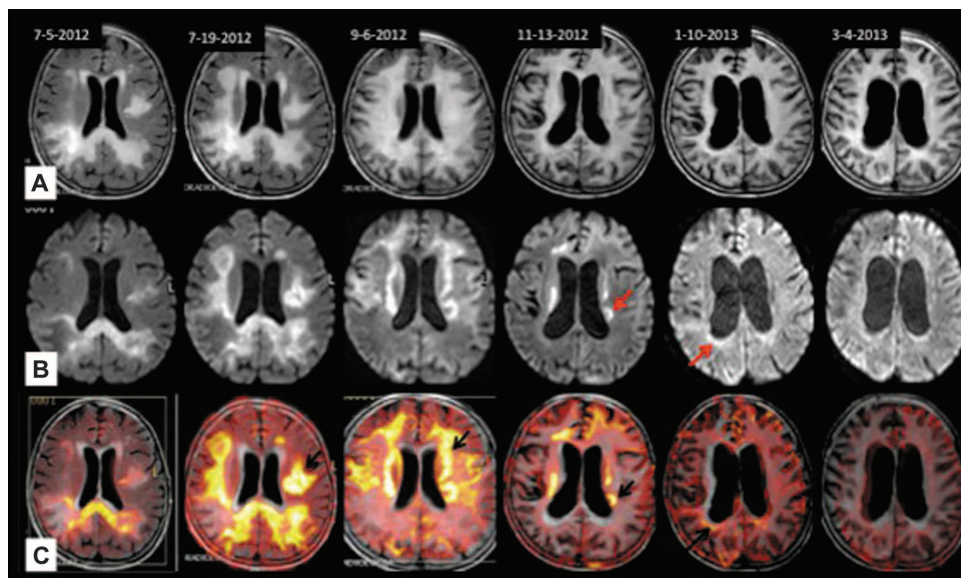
Evolution of PML lesions by magnetic resonance imaging in patient 5228. The patient was initially diagnosed with PML on 24 May 2012. The date of each scan is indicated along the top of the figure. Axial fluid-attenuated inversion recovery (FLAIR, row a), diffusion-weighted imaging (DWI, row b), and FLAIR-DWI merged images (row c) show the evolution of PML lesions. Row a: The first image on the left (July 2012) shows a high signal intensity lesion of the right parieto-occipital white matter extending contralaterally through the corpus callosum; another focus is present in the left subcortical temporal region. Subsequent examinations showed evolution of the signal alteration with progressive rapid extension of the lesions to the entire white matter bilaterally. In September 2012, the white matter was completely occupied by lesional and atrophic processes and enlargements of the ventricles and cortical sulci began to appear. The last examinations (January and March 2013) show progression of atrophy. Row b: Axial DWI images show the evolution of the hyperintense signal alterations corresponding to the front of progression of PML lesions (red arrows). The signal alteration is substantially reduced starting from November 2012 and is no longer visible at the March 2013 examination, implying lesion stabilization. Row c: Merged FLAIR and DWI sequences show, in yellow (black arrows), the initial fronts of advance of PML lesions and their regression over time.
